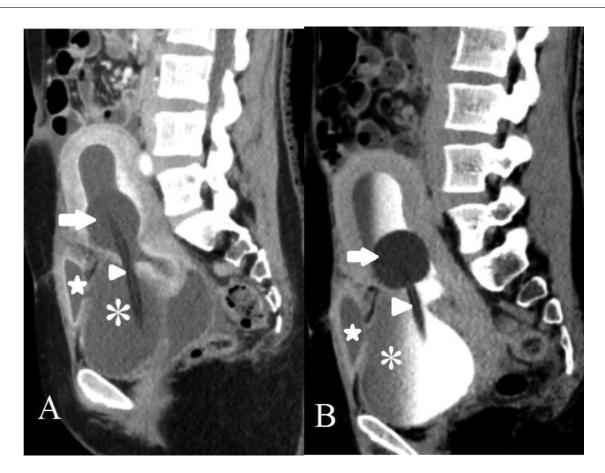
CT scan sagittal view portovenous (A) and delayed phase (B) images showing communication of uterus with urinary bladder (arrow head). Foley catheter passed from urinary bladder (asterisk) is passing through the fistulous tract and entering the uterine cavity (arrow). Hypodense fluid filled collection (star) is noted in the rectus sheath with communication to the urinary bladder.
